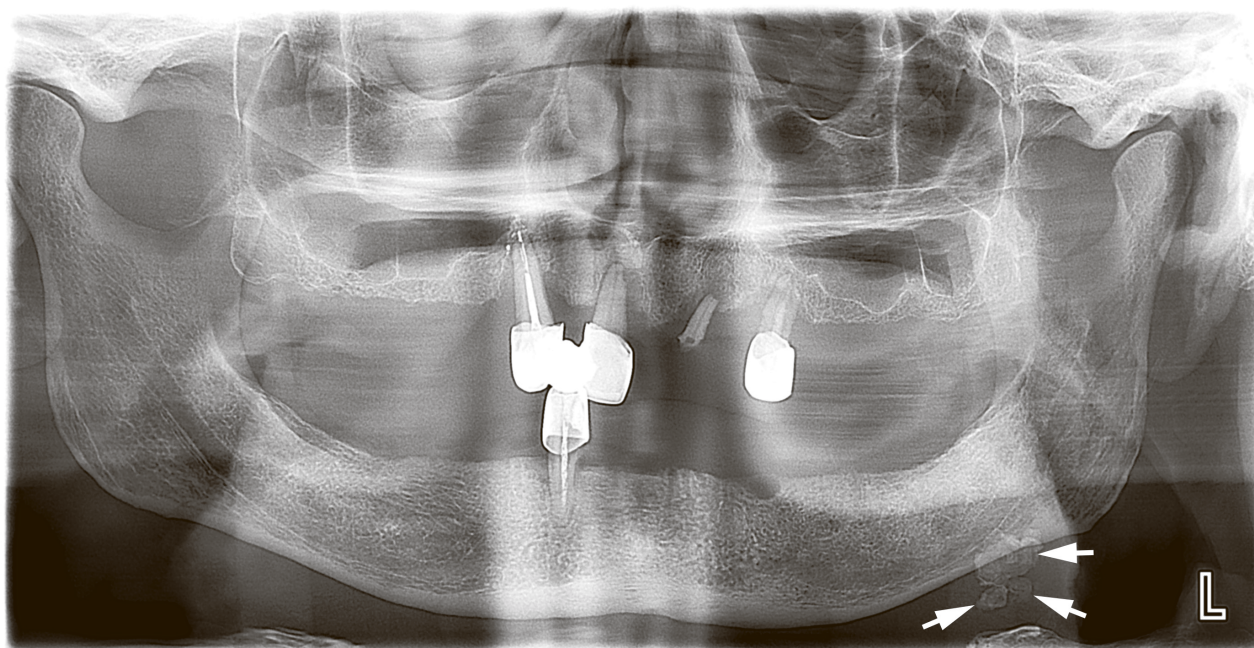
Case 8: An orthopantomogram of 61-year-old gentleman. Notes conglomerate of radiopaque sialoliths (*arrows*) in the projection of left submandibular gland.
